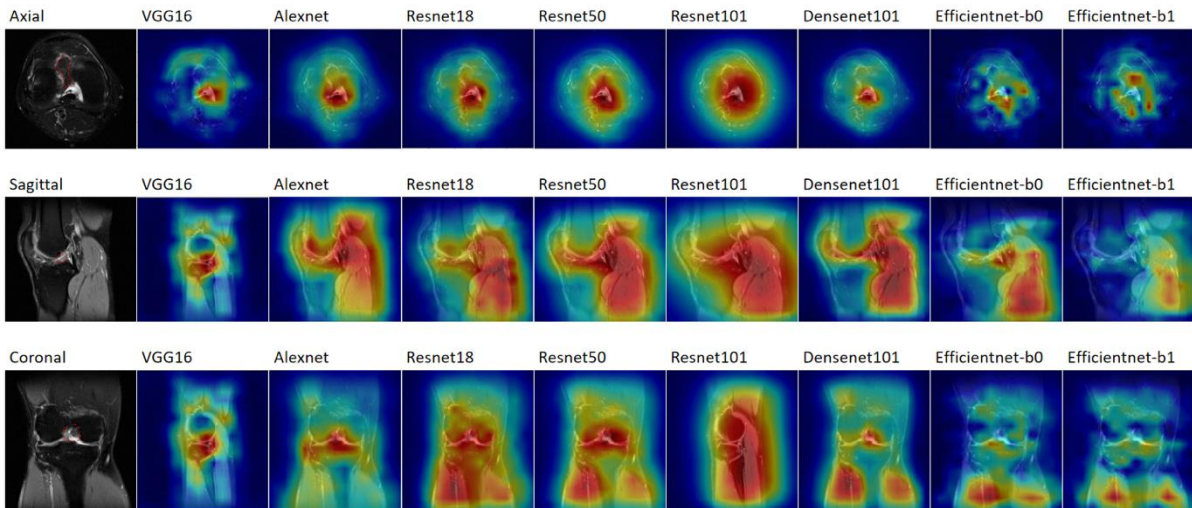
Comparison of class activation mapping. In CAM, the degree of attention that the model pays to regions of interest [26] in the image is represented by color, where red indicates a stronger focus than yellow, and yellow indicates a stronger focus than blue. The red line in the ACL MRI images denotes the area of the lesion.
